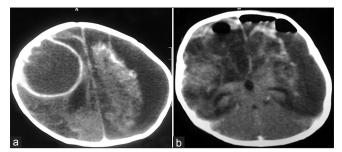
(a) Computed tomography scan showing multiple intracranial abscesses in a two-month old female infant. Note the right fronto-parietal intracerebral abscesses and left-sided subdural empyema. (b) CT showing pneumocephalus after burr hole evacuation of right frontoparietal abscesses. The residual subdural collection was drained under ultrasound guidance
